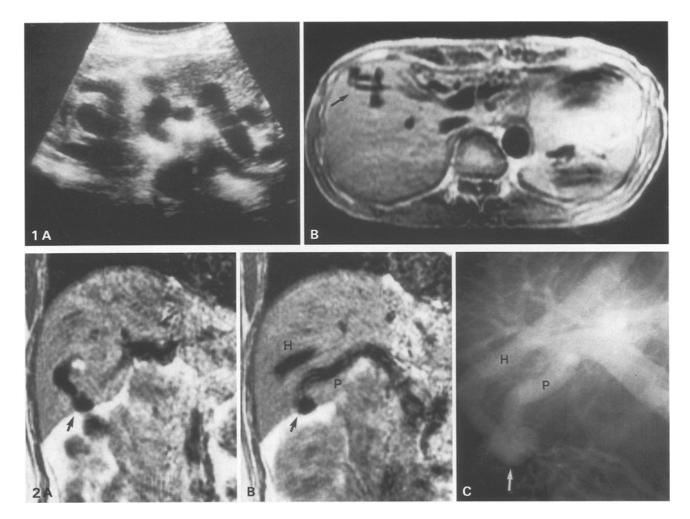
Case 1*. A A transverse ultrasonograph shows unusual blood vessels in the left lobe of the liver. B MRI (TR 2000 ms, TE 20 ms) reveals the unusual vessels and IPHVS (*arrow*).
